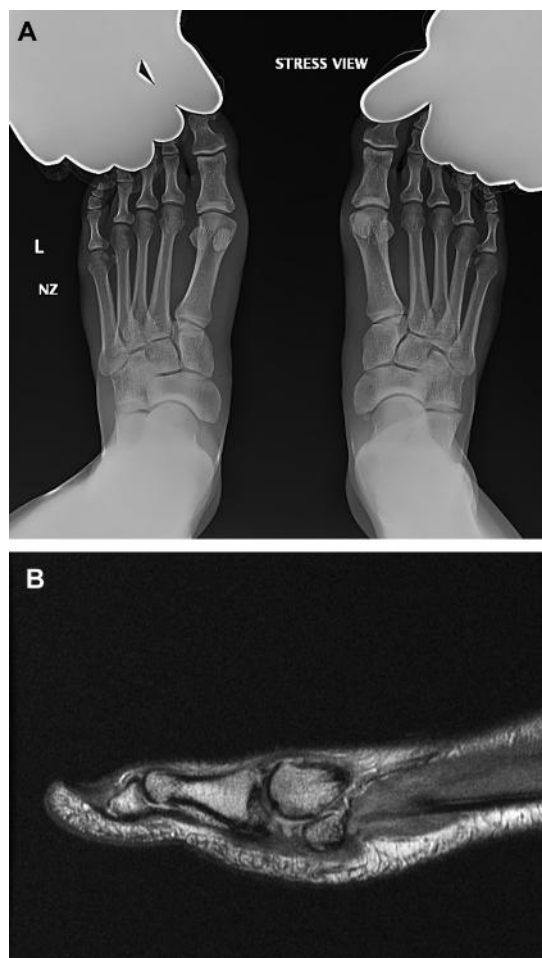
Presentation of acute grade 3 turf toe injury. (A) Example of great toe dorsiflexion stress radiograph indicative of asymmetric proximal migration of hallux sesamoids. (B) Example of complete disruption of the medial sesamoid phalangeal ligament with proximal retraction of the hallux sesamoid and disruption of the plantar plate.
